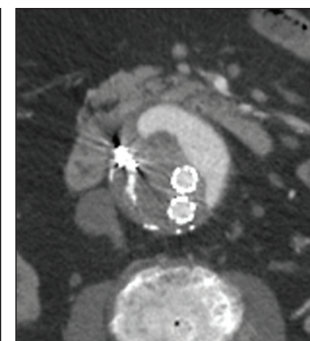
Three-year follow-up CT scan showing a recurrent type I endoleak.
